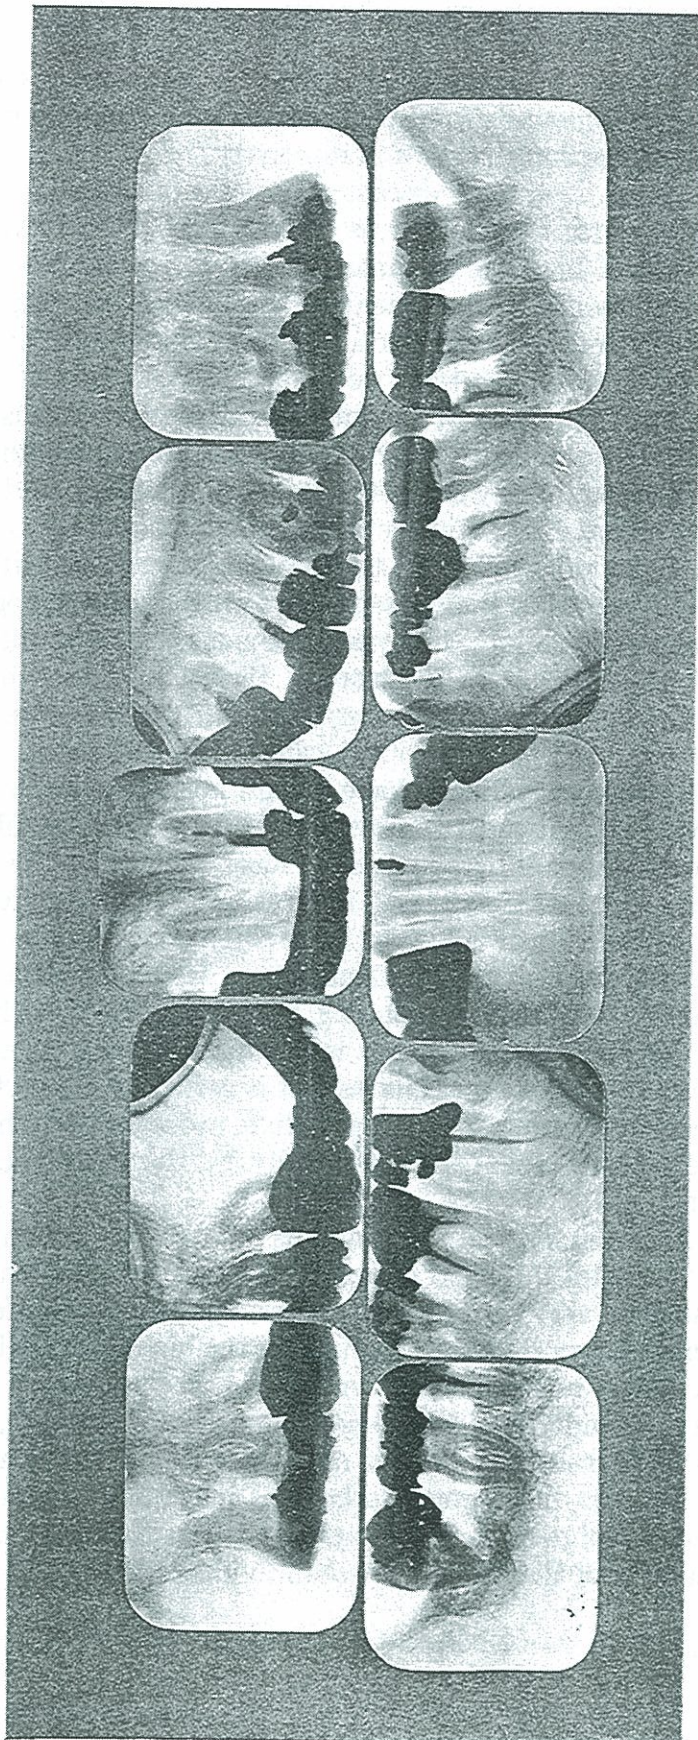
ROENTGENOGRAPHIC RECORD OF THE TEETH OF THE PATIENT SHOWN IN FIGURE 175.
